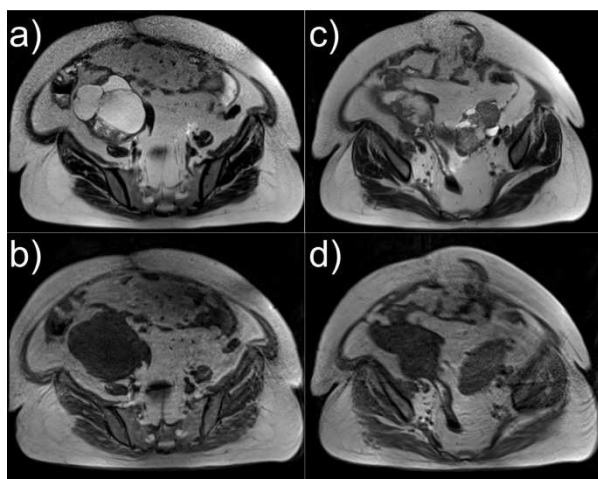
Magnetic resonance imaging (MRI) of pelvic for ovarian masses without contrast
